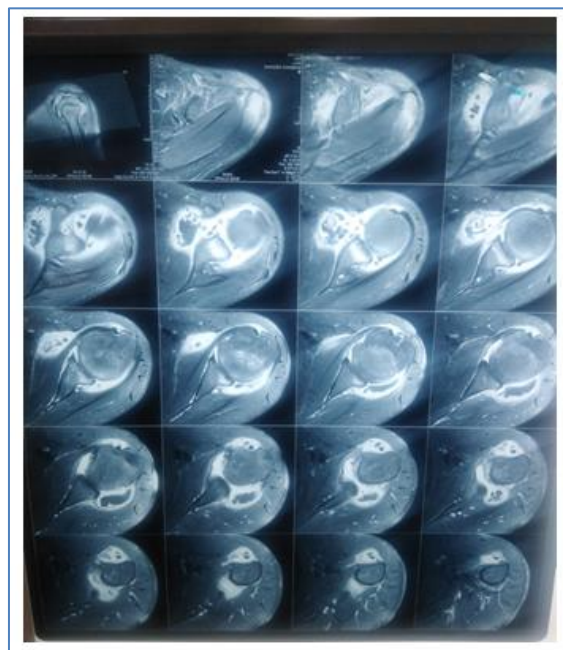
Axial MRI demonstrating location and morphology of calcified loose bodies within glenohumeral joint
